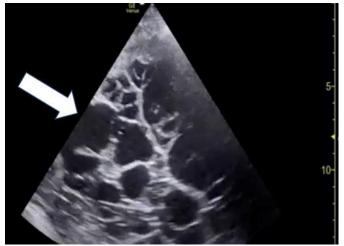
Point-of-care ultrasound in transverse view of the left hemethorax depicting a large, loculated pleural effusion (thick arrow).
